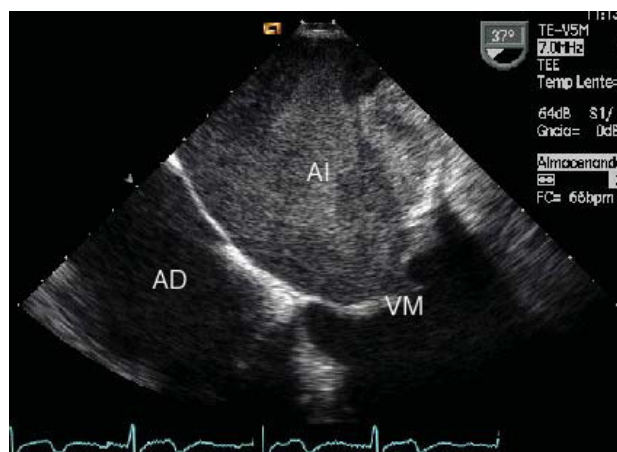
Transesophageal echocardiography in a patient with mitral stenosis. The left atrium is full of spontaneous contrast. RA indicates right atrium; MV, mitral valve; LA, left atrium.
